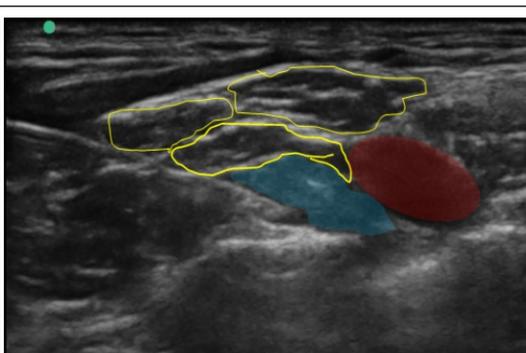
Ultrasound Corner pocket
